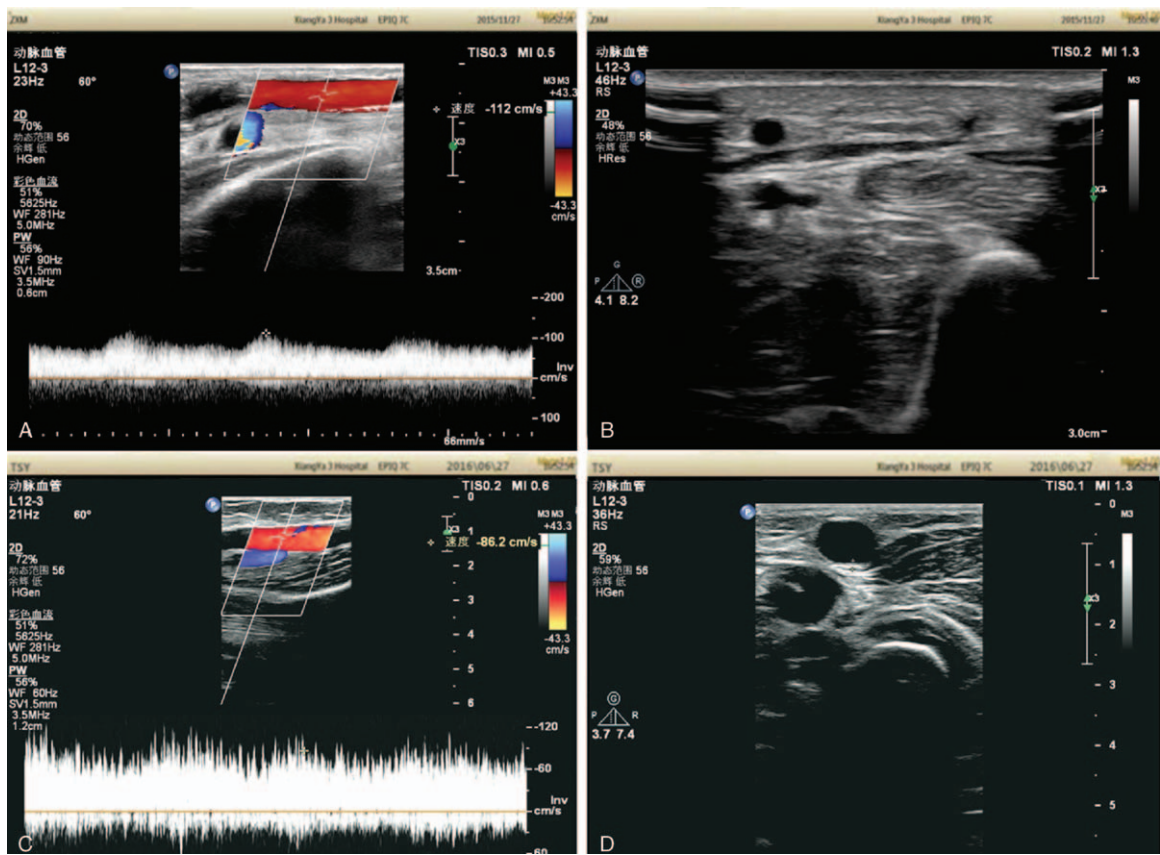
Typical color Doppler ultrasound images of the distal end of the arteriovenous fistula. (A and B) Control group; (C and D) Trial group. (C cf. A) The longitudinal section of the blood vessel shows the upper vein wall becoming thicker two years ago when the blood flows in the continuous spectrum. (D cf. B) The transverse section of the blood vessel shows the upper vein wall becoming thicker 2 years ago and shows the vein vessel diameter enlarging in the trial group.
